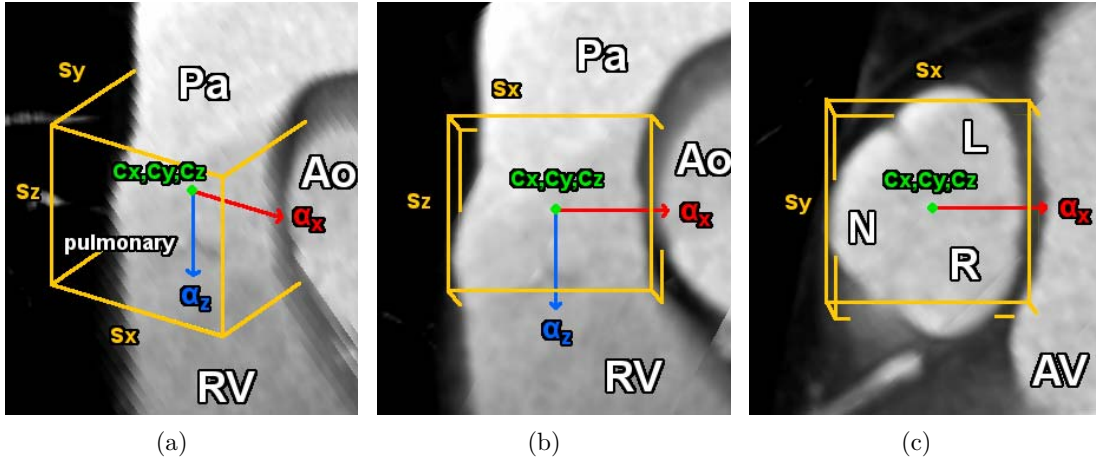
Similarity transform represented as a bounding box around the pulmonary valve from cardiac CT. (a) Perspective view; (b) Long Axis; (c) Short Axis.
